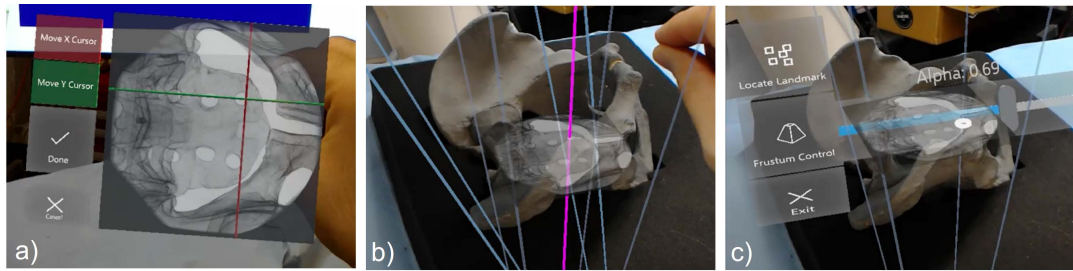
a) Annotation on selected X-ray image. b) The resulting ray connecting the C-arm source and the annotation point. c) Adjustable transparency of each X-ray image.
